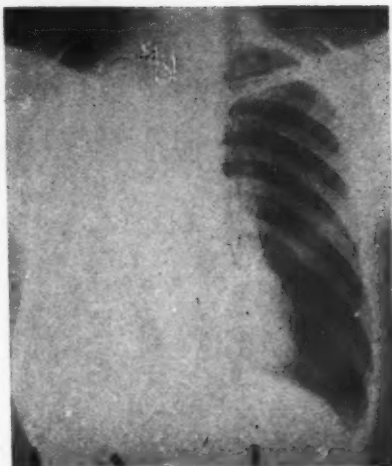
Radiograph of patient taken four years later. For past two years patient has been able to engage in light work and is enjoying good health. The dense homogeneous shadow of the right side is typical in appearance of post total pneumonectomy operations. It is caused by thickened pleura and fibrinous organization.
